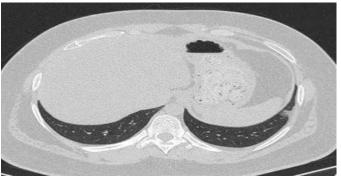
Ground glass opacities (GGO's) are noted in the left lower lobe predominantly peripheral in distribution. Early CT in <4 days of symptom onset.
